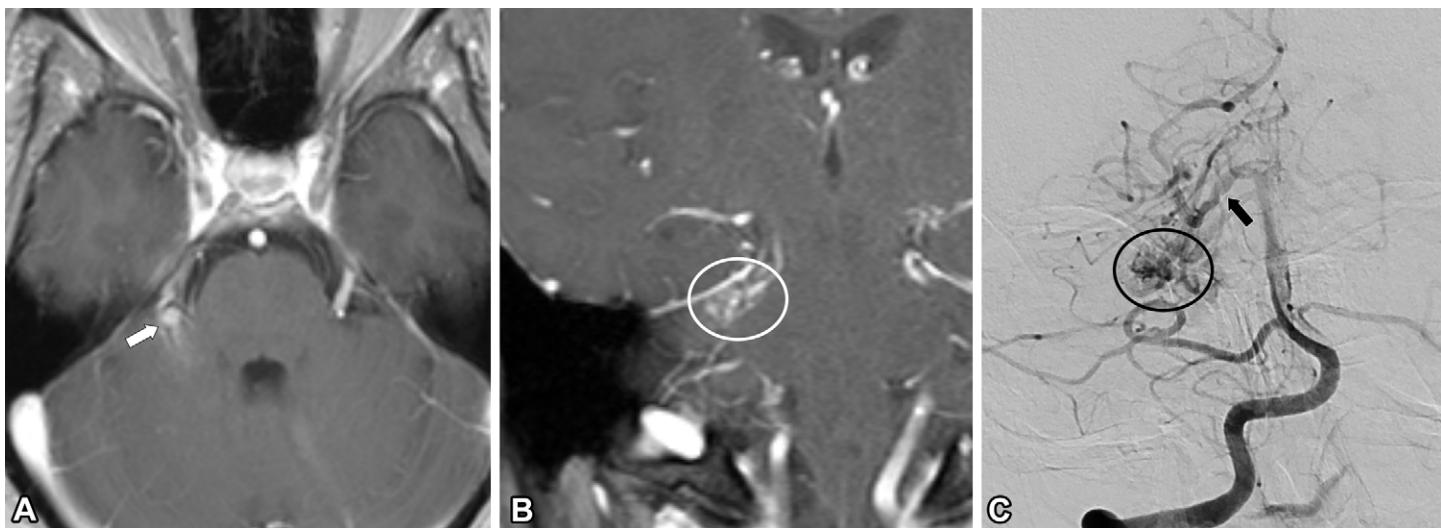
Arteriovenous malformation of the right middle cerebellar peduncle in a 34-year-old patient who underwent MRI with an IAC protocol for workup of right-sided pulsatile tinnitus. (A) Axial contrast-enhanced T1-weighted image shows an area of enhancement (arrow) in the right middle cerebellar peduncle. (B) Coronal postcontrast MR image shows a tangle of vessels (oval). The patient underwent DSA. (C) Frontal angiogram obtained with a right vertebral artery injection shows a cerebellar arteriovenous malformation (oval) with an early-draining deep cerebral vein (arrow). The patient elected radiation therapy.
